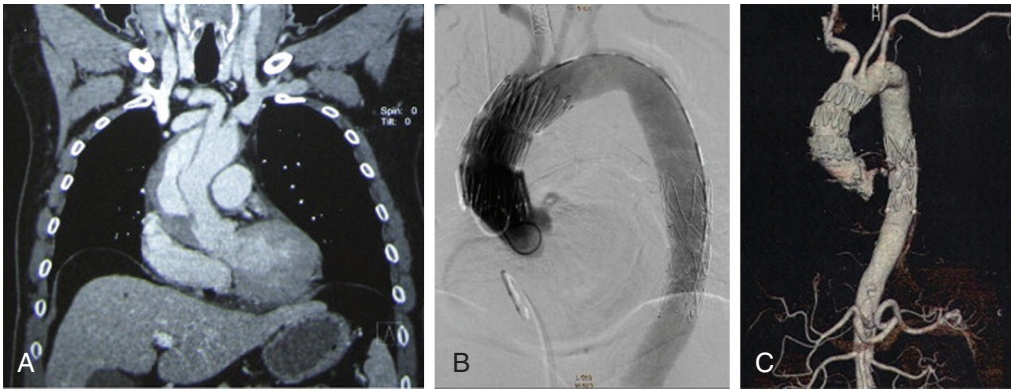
FIGURE e57-16 TEVAR of chronic ascending aortic dissection with treatment of the intimal tears in the ascending and descending aorta in one setting. A, CTA demonstrating an intimal tear in the ascending aorta and false lumen patency 36 days after acute type A dissection. B, Completion aortography after TEVAR demonstrating patency of the arch vessels. C, CTA at 24 months demonstrating complete thrombosis of the false lumen after TEVAR of the ascending aorta and descending aorta. (From Lu Q, Feng J, Zhou J, et al: Endovascular repair of ascending aortic dissection: A novel treatment option for patients judged unfit for direct surgical repair. *J Am Coll Cardiol* 61:1917, 2013.)
